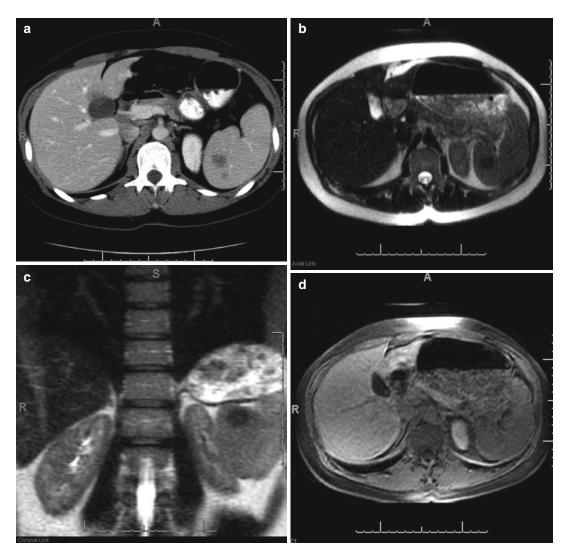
A 29-year-old female with incidentally noted splenic lesions. Axial-enhanced CT (\mathbf{a}) image demonstrates non-enhancing splenic lesions with decreased signal intensity on axial (\mathbf{b}) and coronal (\mathbf{c}) T2-weighted signal shot fast spin
